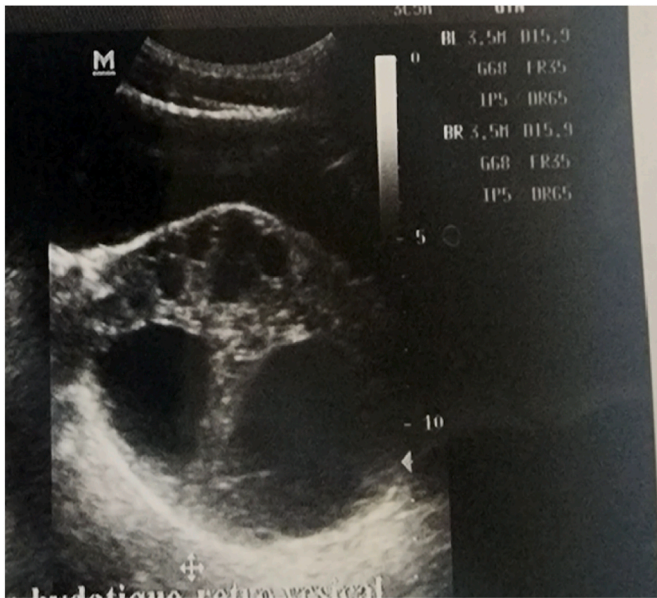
Ultrasound showing a multiloculated, type III Gharbi classification retrovesical cystic mass.
